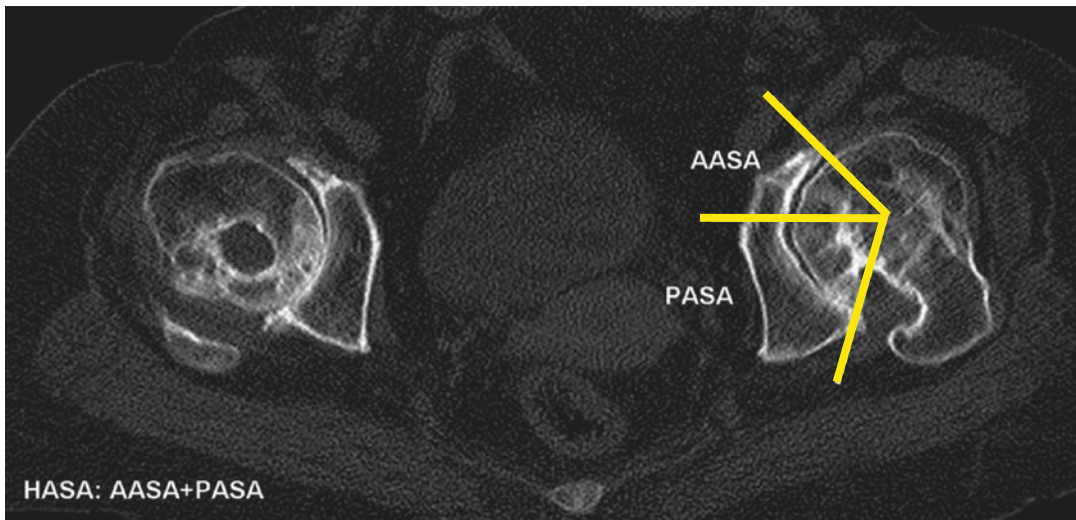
AASA and PASA assessment on CT axial image
